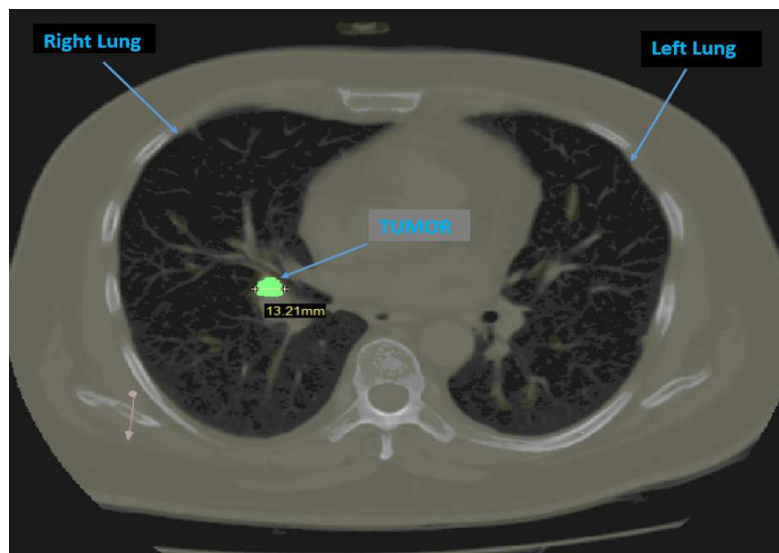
2D Image from CT (Computer Tomography) of Lung and Tlung Tumor
